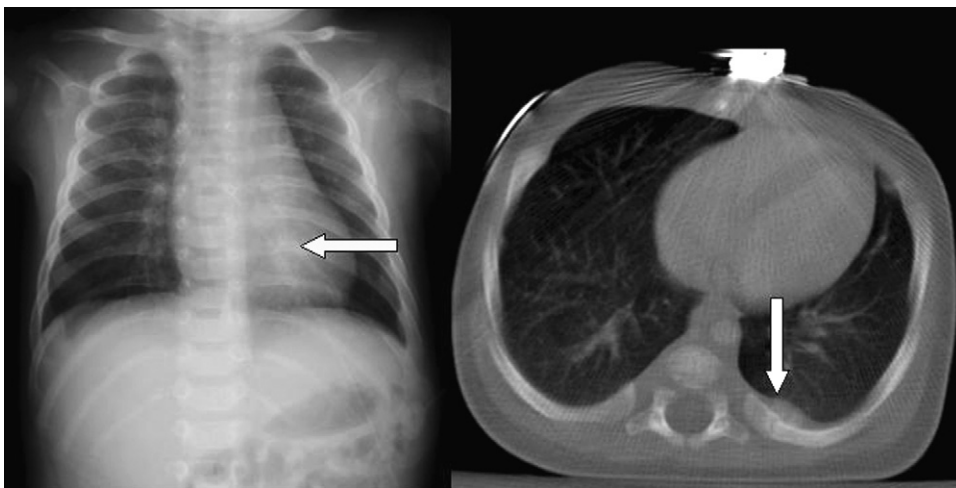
Eighth left acute posterior rib fracture seen by CT but not by CXR. Adjacent subperiosteal hemorrhage is also noted on the CT scan.
